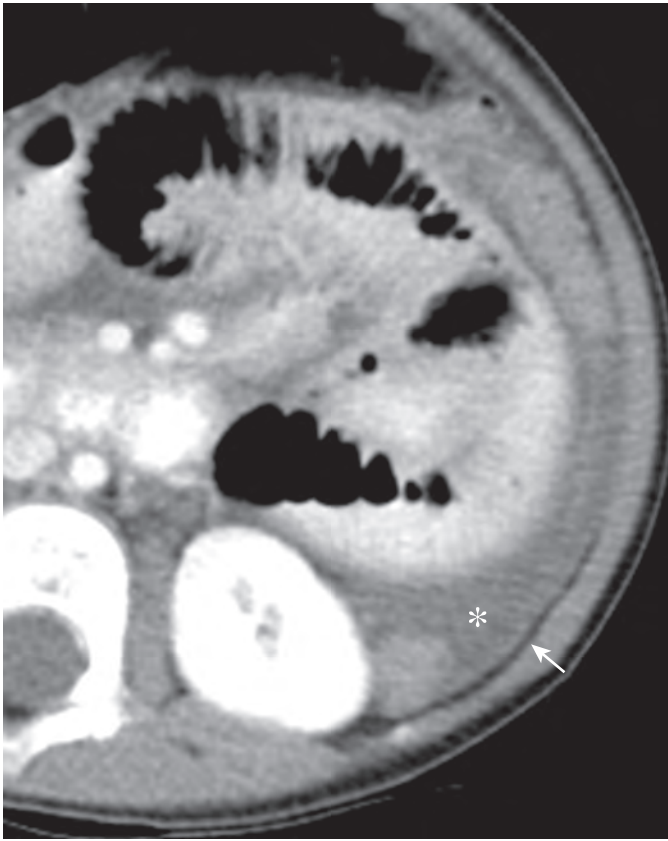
Peritonitis. A 3-year-old boy presenting with diffuse abdominal pain and physical examination findings consistent with peritonitis. Axial contrast-enhanced CT of the abdomen and pelvis revealed peritoneal thickening and enhancement (arrow) with complex ascites (asterisk). Surgery confirmed perforated appendicitis (not shown).
